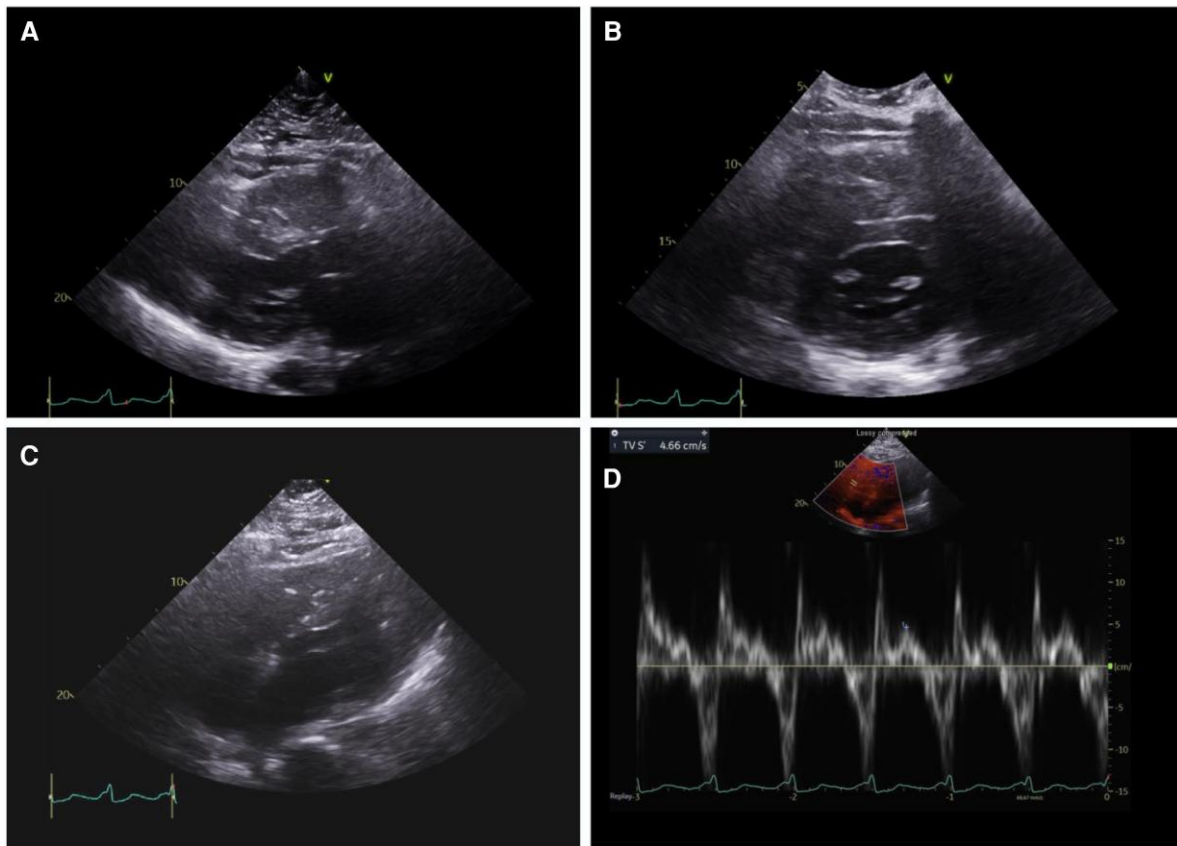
Echocardiography at the time of intensive care unit admission. (A, B) Parasternal views showing markedly depressed systolic function of both ventricles. (C) RV-focused view demonstrating hypokinesia of the RV free wall with reduced annular excursion. (D) Tissue Doppler showing reduced tricuspid annular systolic velocity (S' 4.7 cm/s). RV, right ventricle.
